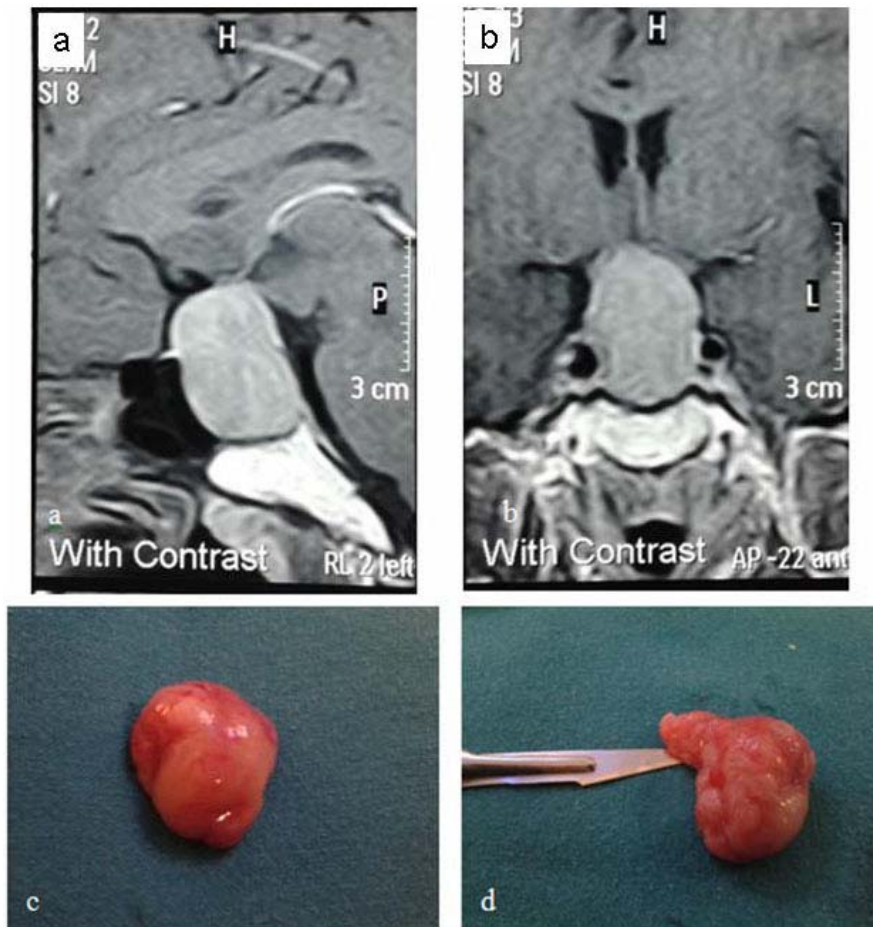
Extra-capsular en block excision of pituitary adenoma. a&b: sagittal and coronal section of preoperative MRI of a case of non functioning adenoma. c&d: mass after enblock excision.
